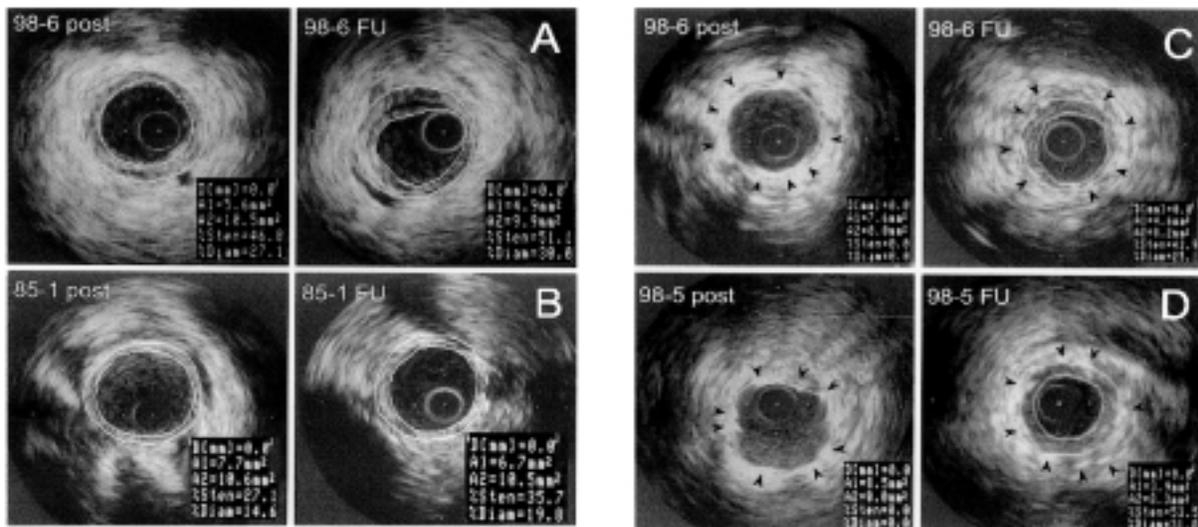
Intravascular ultrasound (IVUS) cross sections from coronary arteries treated by PTCA (A, B) or stent placement (C, D), and with vehicle- (A, C) or rFGF-2- (B, D) treated coronary artery immediately after (left panels, post) intervention and at follow-up (right panels, follow-up [FU]) 6 weeks later. Lumen and media-bounded areas were manually traced and their measures displayed (A1 and A2, respectively) in the insets. Abbreviation as in Fig. 1.
